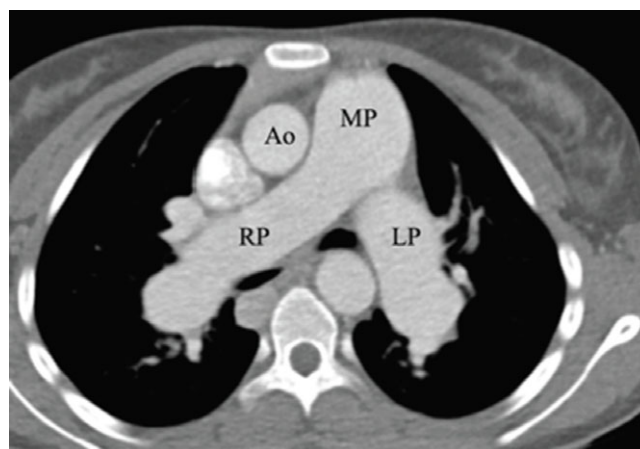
CT axial image demonstrating marked enlargement of the main pulmonary arteries (MP) as well as right and left branch pulmonary arteries (RP and LP, respectively). Note that each branch pulmonary artery is larger than the aorta (Ao).
